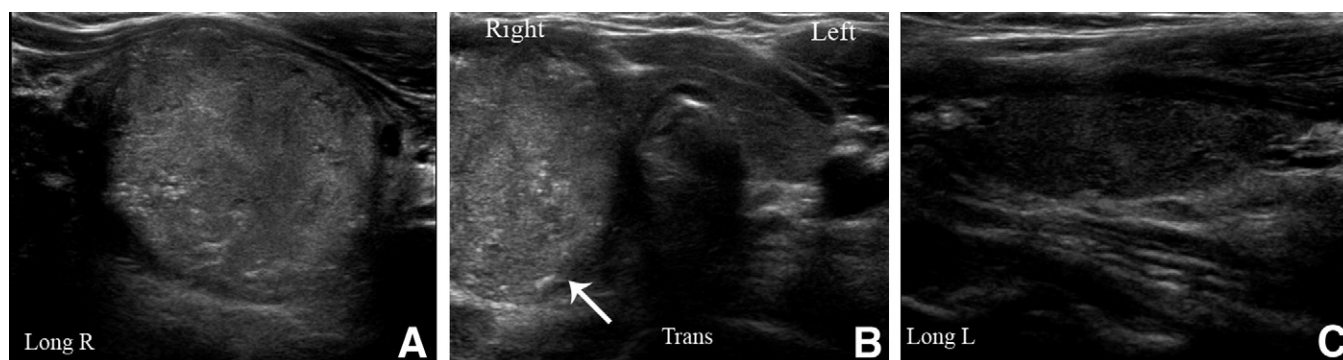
Longitudinal right (A); transverse (B), and longitudinal left (C) views from a thyroid ultrasound in a 15-year-old patient presenting with an 11-month history of weight loss, hoarseness, difficulty swallowing and a palpable right sided neck mass. The right lobe of the thyroid is markedly enlarged and heterogenous with punctate calcifications (A; arrows B); the left lobe of the gland is normal (C). FNA with ultrasound guidance, the preferred method of evaluating a thyroid nodule, confirmed papillary thyroid carcinoma. The likelihood of malignancy in a palpable thyroid nodule increases if there has been rapid growth, if the mass is hard or adherent to surrounding tissues, associated with vocal cord paralysis or cervical adenopathy.
